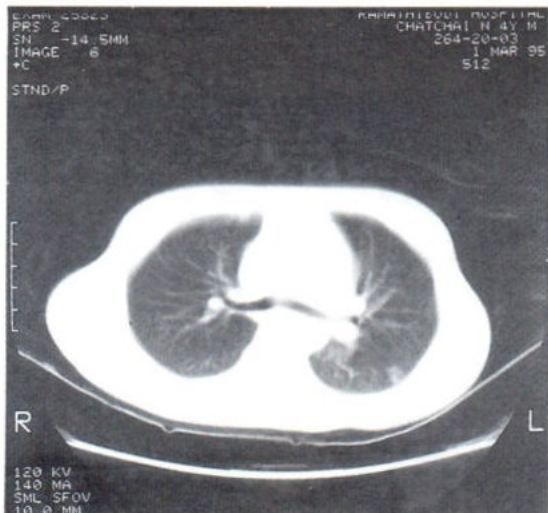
CT scan of the thorax in the same patient showed pulmonary nodule in the left lung which was not radiated.
